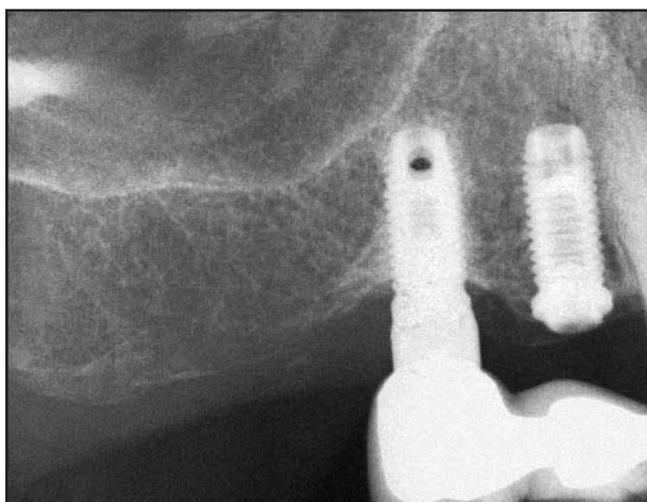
Eleven-year follow-up demonstrates crestal bone remodeling to approximately the first thread on the restored and functioning implant, with no radiographic crestal bone change observed around the mesial implant, which is still covered with soft tissue.
